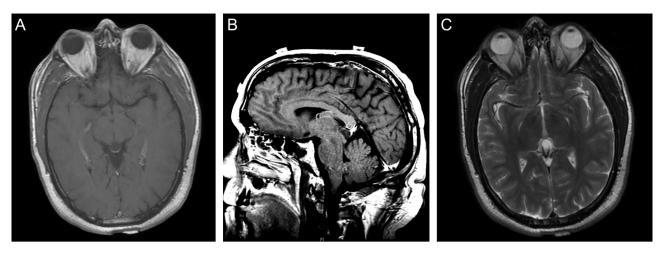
Preoperative magnetic resonance imaging demonstrated a pineal cyst in the quadrigeminal cistern. (A) T1 axial post-contrast; (B) T1 sagittal post-contrast; (C) T2 axial.
